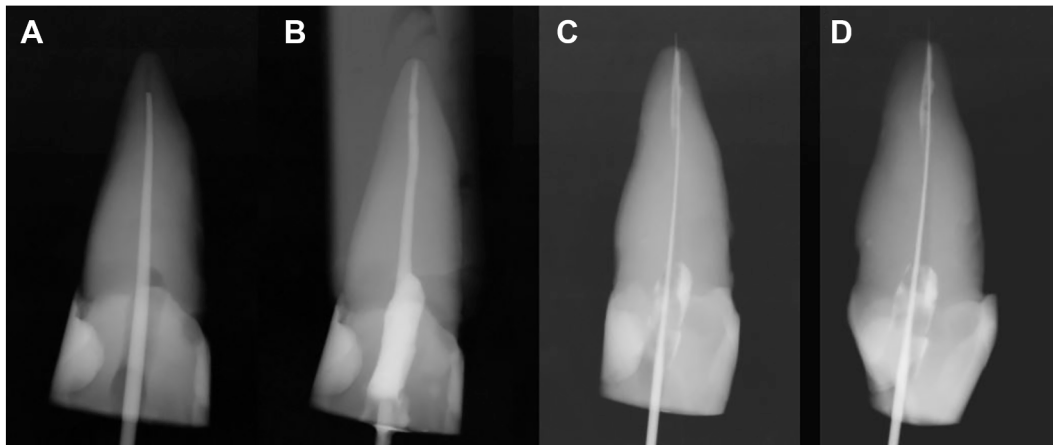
Radiographic evaluation of endodontic treatment stages and apical patency. Initial cone-beam radiograph demonstrating the master gutta-percha cone positioned 2 mm short of the working length (A). Postoperative radiograph showing completed root canal obturation (B). Radiographic evidence of the retreatment process and confirmation of apical patency achievement, in both buccolingual (B-L) and mesiodistal (M-D) orientations (C and D).
